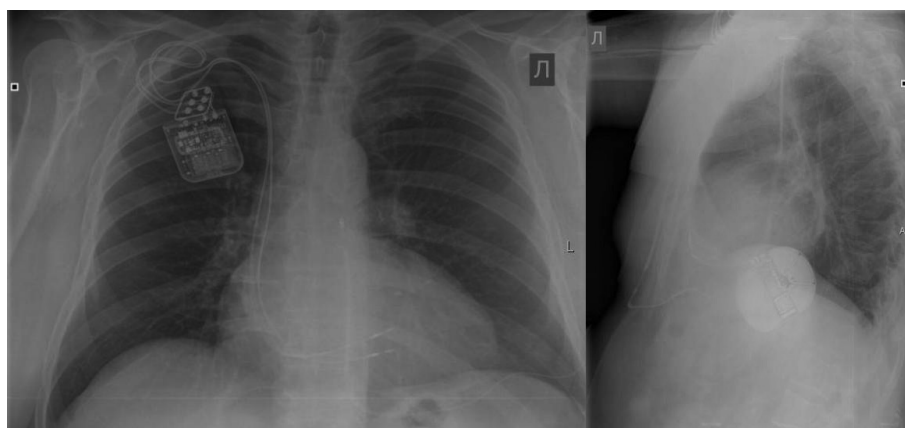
Chest X-ray of the patient after implantation of the CCM device and subcutaneous ICD system.
